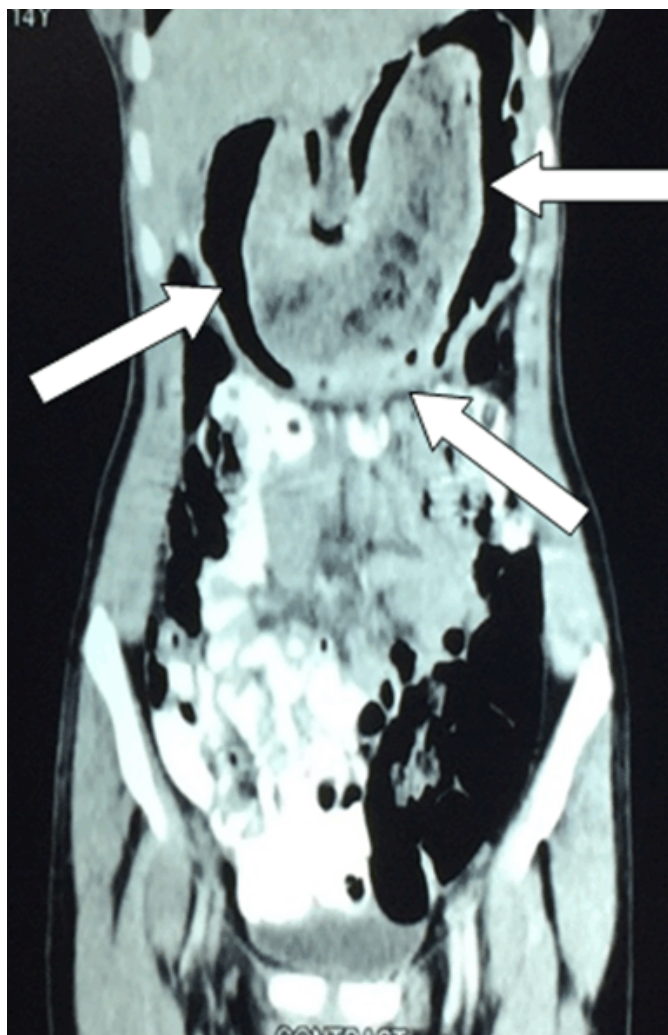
CT scan image showing the hairball inside the gastric cavity (white arrows).
